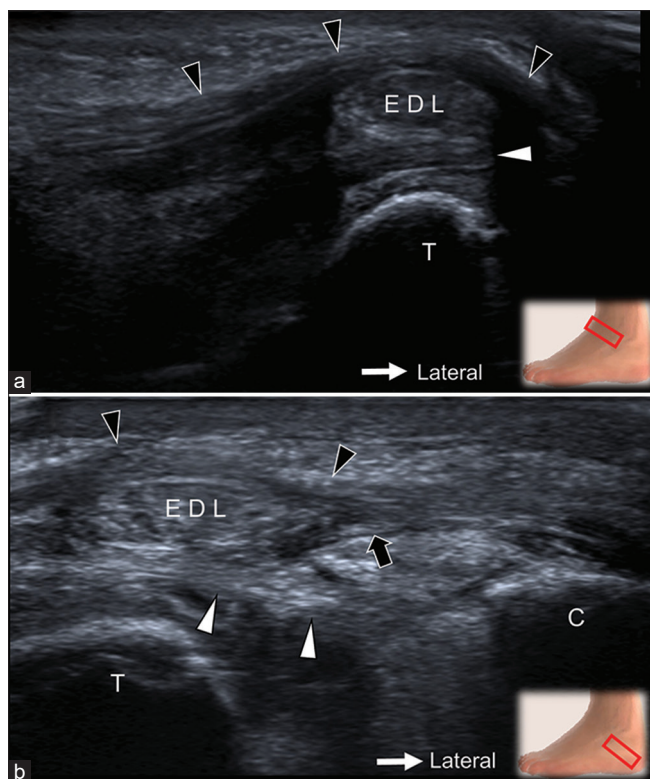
Ultrasound imaging of the right anterolateral (a) and inferolateral (b) ankle. Black arrowheads: Lateral root of the inferior extensor retinaculum, black arrow: Intermediate root of the inferior extensor retinaculum, white arrowheads: Medial root of the inferior extensor retinaculum, T: Talus, C: Calcaneus, EDL: Extensor digitorum longus tendon
